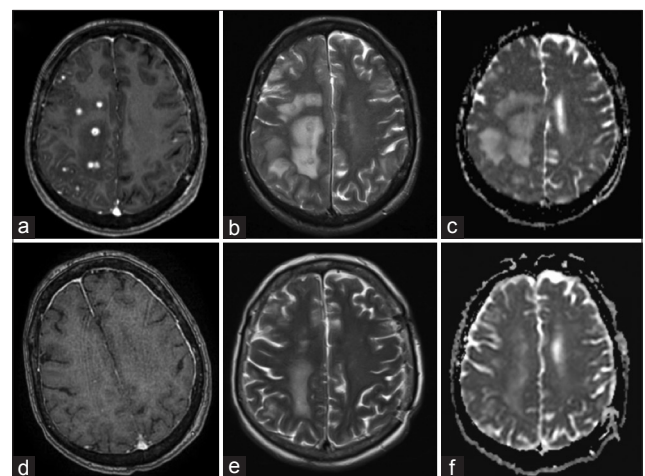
(a) T1-weighted (T1W) axial MRI with gad shows multiple ring-enhancing abscesses in the right frontal, parietal, and occipital lobes with surrounding edema. (b) Corresponding T2-weighted (T2W) axial image showed multiple hyperintense centers and hypointense irregular rims. (c) The abscesses appear isointense with areas of hypointensity on apparent diffusion coefficient (ADC) map suggestive of restricted diffusion. One month after the commencement of antimicrobial therapy, MRI demonstrated resolution in many of the enhancing foci with significant decrease in the size of the surrounding vasogenic edema (e-f)
